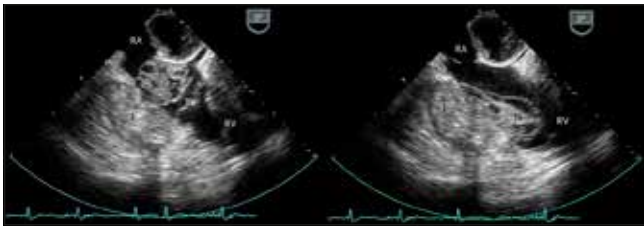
Trans-oesophageal echocardiogram images demonstrating a large mass (M) arising in the right atrium (RA) and prolapsing through the tricuspid valve (TV) into the right ventricle (RV), during the cardiac cycle, with evidence of intramural invasion (I).
